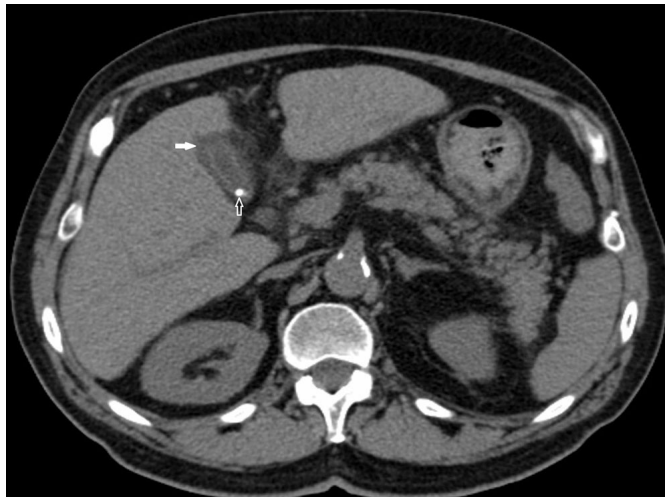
A 71-year-old female patient. Chronic cholecystitis was evident on abdominal CT, as indicated by the increased wall thickness of the gallbladder, without distention (white arrow), and a millimeter-scale calcified stone (open arrow)
